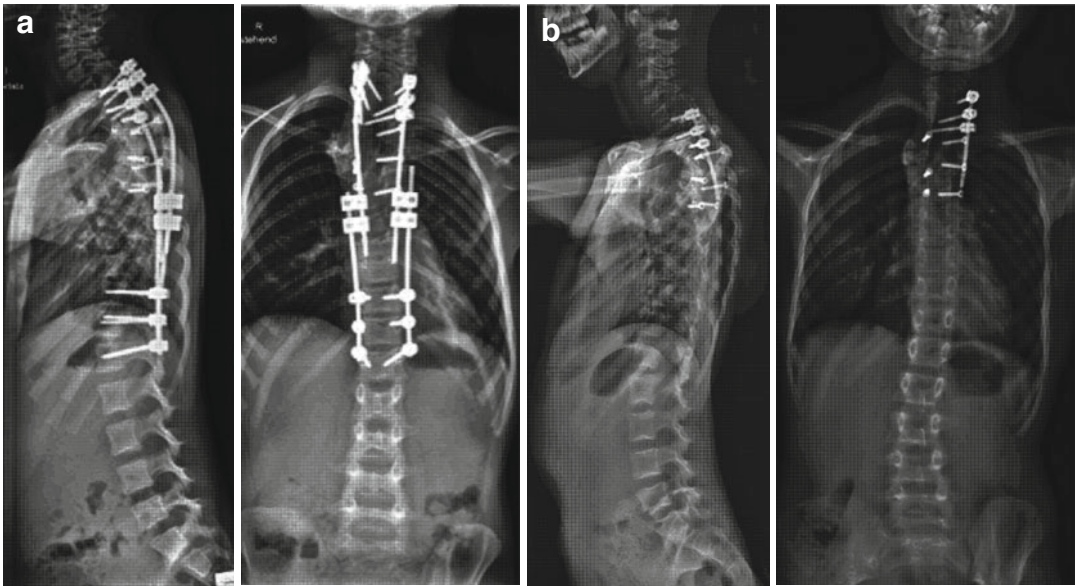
Segmental instrumentation was replaced by a double growing rod construct after 3.6 years (a) followed by multiple distractions. The curvature improved during continued growth and the non-fusion instrumentation could be partially removed, i.e. shortened (b, radiographs
